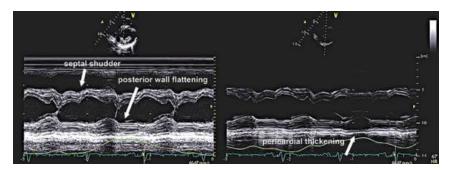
CP: M-mode of parasternal short-axis view in the same patient as in Figure A13. Several M-mode features of CP are seen, including diastolic flattening of the posterior wall, pericardial calcification (better seen in the *right panel* with a reduced 2D gain and fundamental imaging), a septal diastolic shudder consistent with the septal bounce seen by 2D imaging, and respiratory variation in LV cavity size.
